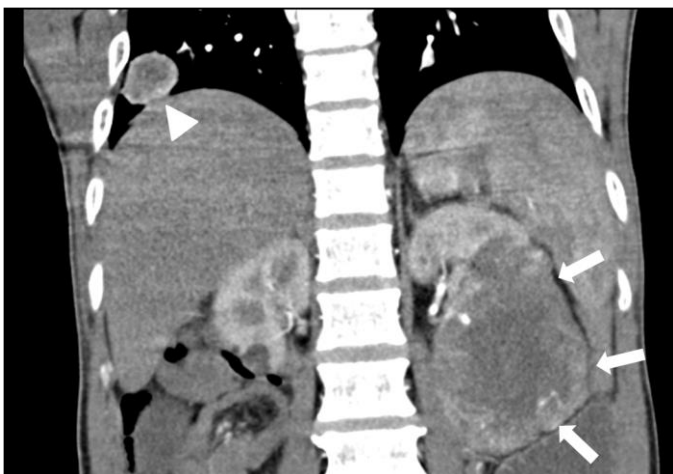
(left). 52 year old male patient with left renal cell carcinoma and a metastatic ileo-ileal intussusception. Coronal multiplanar reconstruction of a contrast enhanced CT in the arterial phase shows a large irregular heterogeneous mass lesion arising from the lower pole of the left kidney (solid white arrows) measuring 10.1 x 7.8 x 7.5 cm (anteroposterior x mediolateral x superoinferior). Also note the enhancing metastatic nodule in the lower lobe of the right lung (arrowhead). TECHNIQUE: Coronal CT reconstruction. 105 mAs, 120 kV, 1 mm slice thickness, 80 ml iohexol.
